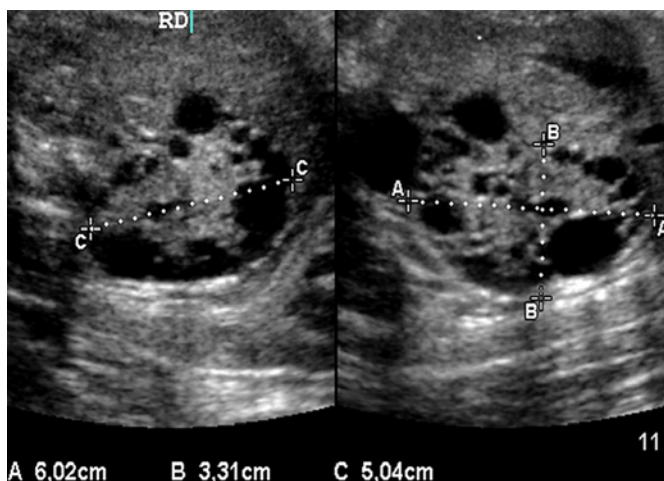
Fetal ultrasound performed at 30 weeks of gestation showing the right kidney (RK) dysplastic with multiple cysts.
